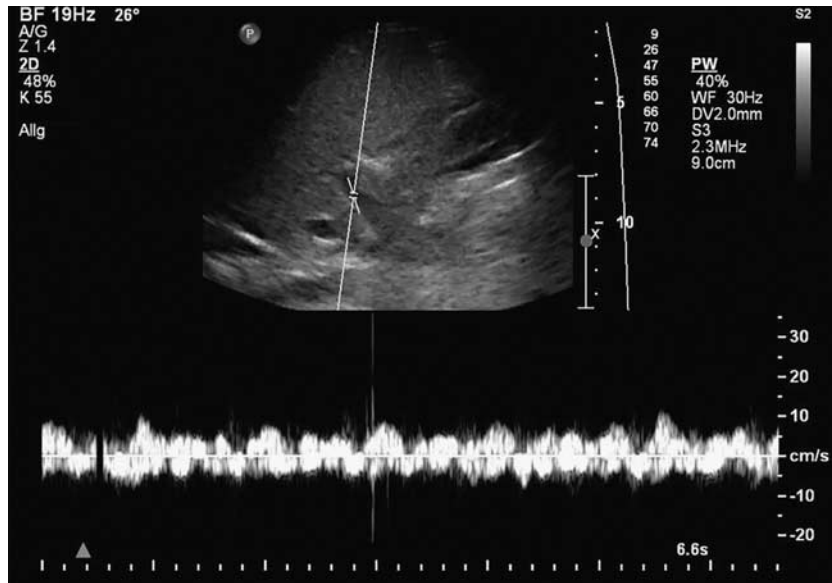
Ultrasound of reduced portal vein flow in patient 1. Lateral intercostal view of the region of the portal vein (C9-3 MHz, iU22, Philips, Eindhoven). Doppler mode showed reduced flow velocity and undulant curve.
